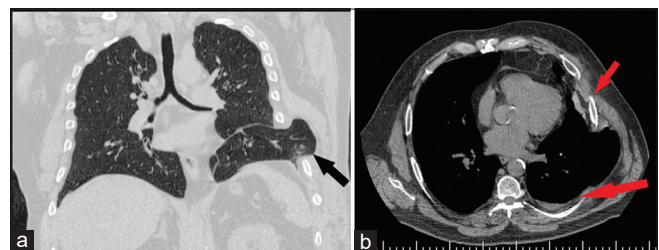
Chest computed tomography obtained 1 h after the initial chest radiograph: (a) herniated lung is pointed by an arrow; (b) the small arrow points the displaced fracture of seventh left rib and the large arrow points fluid into the left costophrenic angle
